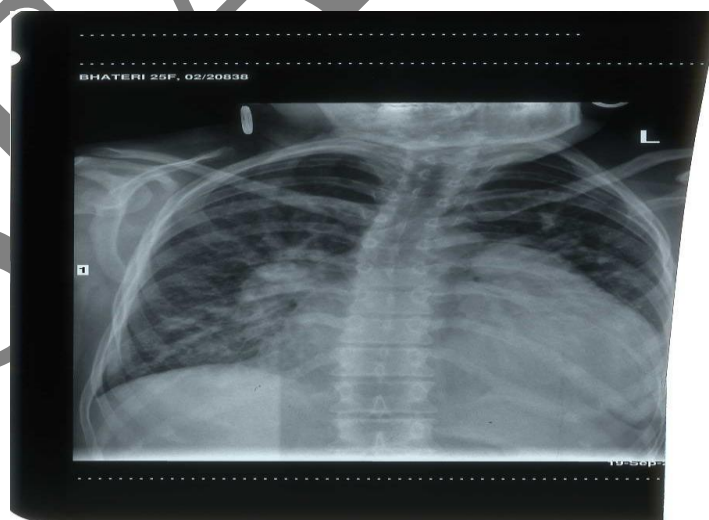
Chest radiograph of the patient showing scoliosis and cardiomegaly
